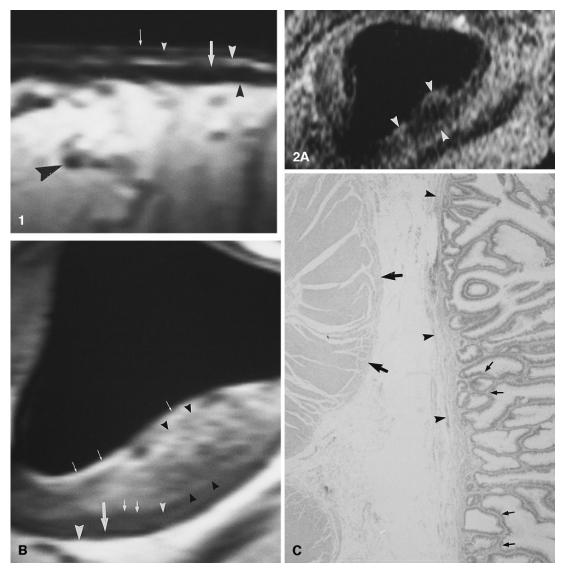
Endorectal MRI of the normal rectal wall (sagittal T1-weighted SE, 700/15). Note the multiple layers visualized in the rectal wall: high signal intensity mucus within the rectal lumen (*thin white arrow*), low signal intensity mucosal layer (mucosa and muscularis mucosa) (*small white arrowhead*), high signal intensity submucosal layer (*large white arrowhead*), low signal intensity muscularis propria (*white arrow*), and high signal intensity perirectal fat (*small black arrowhead*), vessel (*large black arrowhead*).
